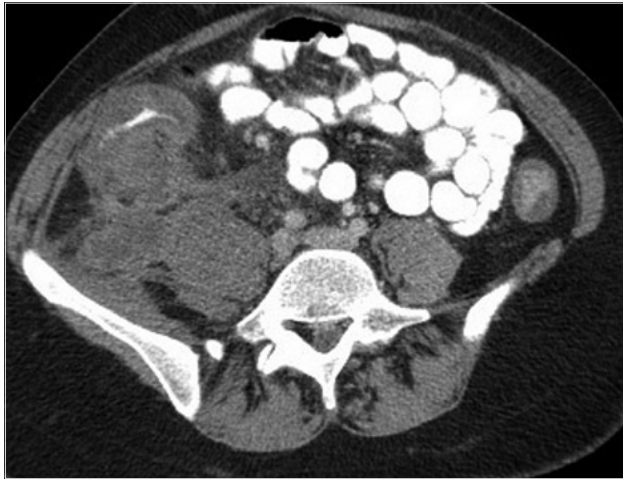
Inflammatory mass and abscess formation around the cecum on computed tomography (CT)
